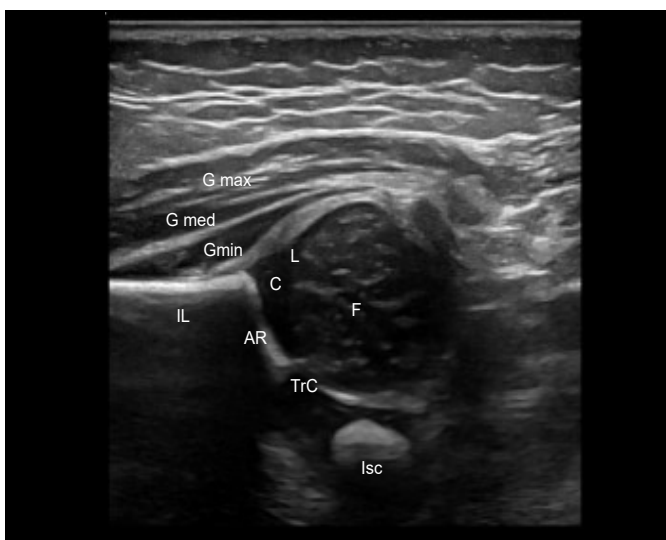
Labeled Coronal ultrasound image
